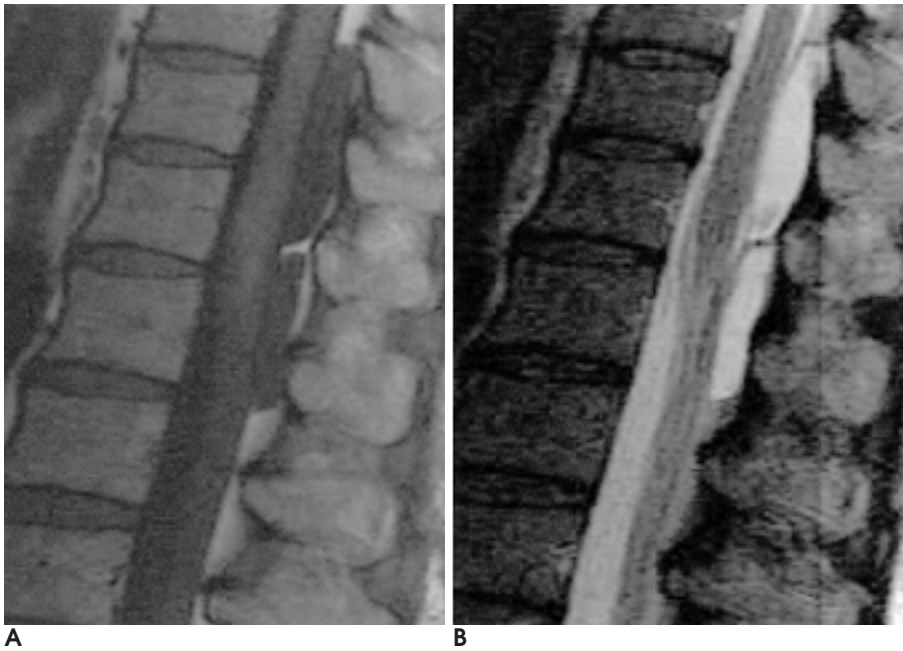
A 40-year-old man with thoracic extradural arachnoid cyst. Sagittal T1-(A) and T2-weighted (B) images show a lobulated mass with isosignal intensity relative to CSF.
